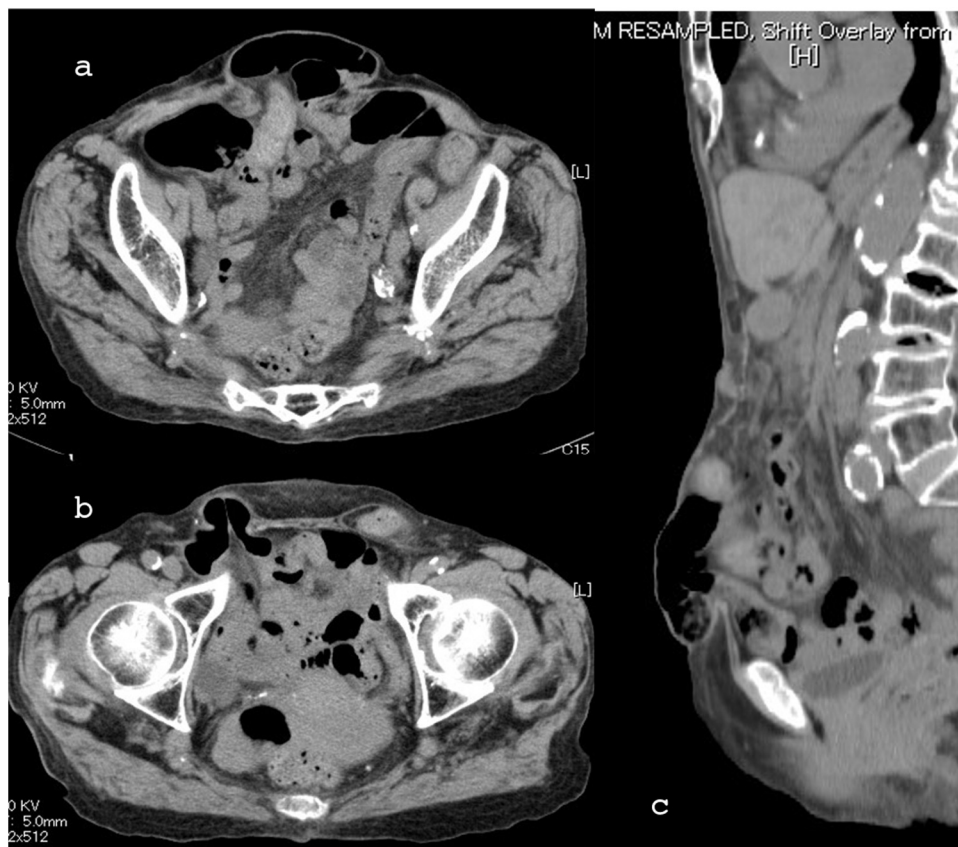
Preoperative abdominal CT scan.
